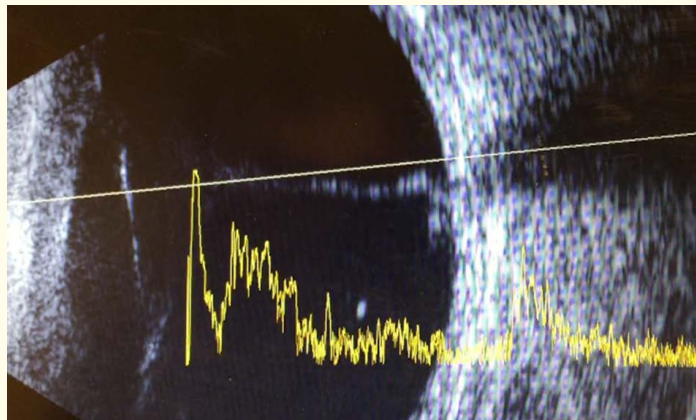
B-scan ultrasound of the left eye 3 weeks after presentation shows funneled retinal detachment.
